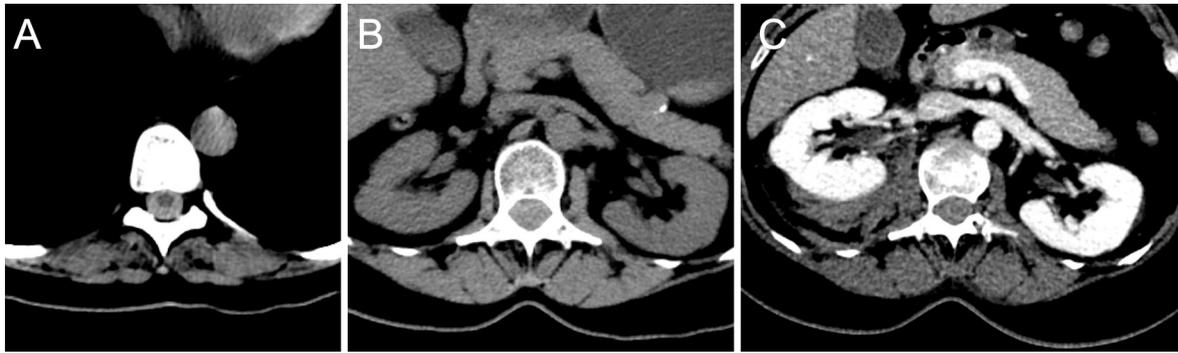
Axial non-contrast CT images obtained a few hours following initial presentation from outside hospital reveals extensive subarachnoid hemorrhage in the thoracic (A) and lumbar (B) regions without perinephric hematoma. Two days later, follow-up CT revealed right sided perinephric retroperitoneal hematoma (C).
